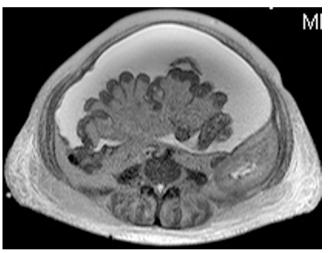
An MRI scan showing the same features in the same patient, with subtle differences. The calcification is not as prominent, and the thickening of the peritoneum is not as evident in MRI scan compared to the CT scan
